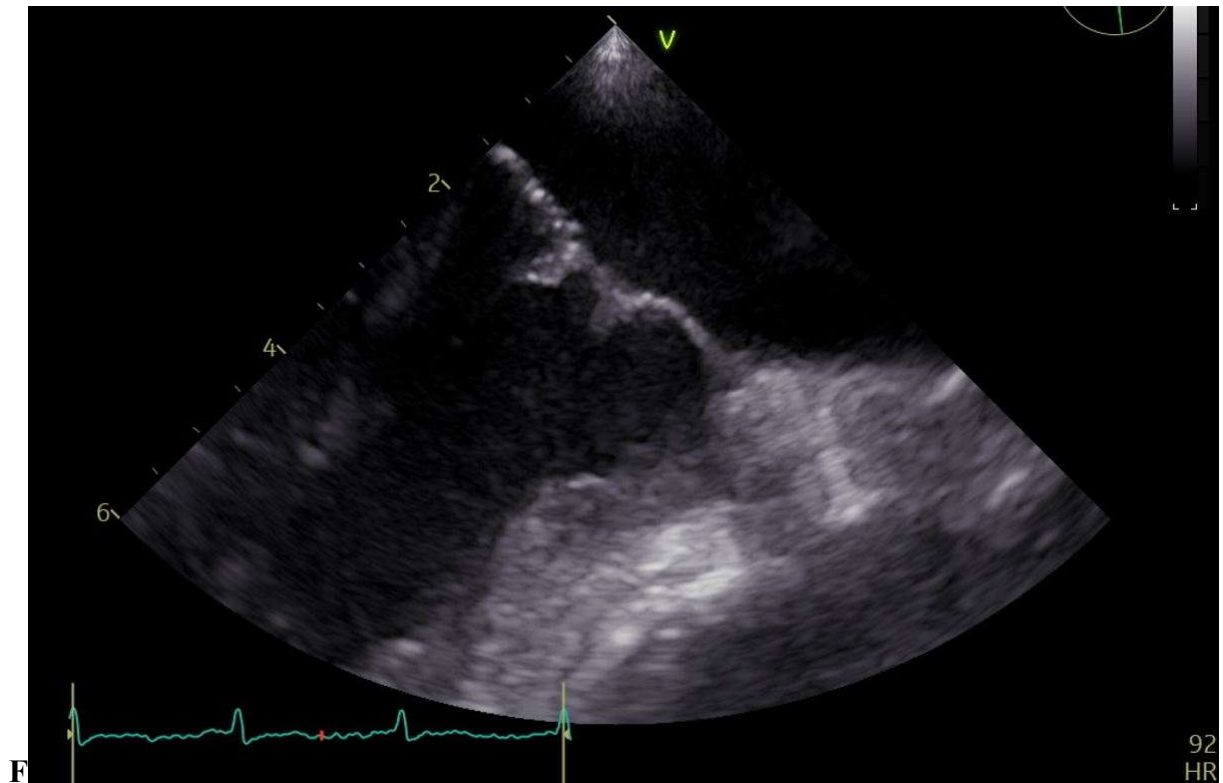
A. Severe mitral regurgitation (MR) in the 4-chamber view on transthoracic echocardiography (TTE); vena contracta measures 9 mm. B. Central large jet >50 % of the left atrium area. C. Severe MR in the 3-chamber view on TTE; proximal isovelocity surface area measures 10 mm. D. Mild to moderate MR in the 4-chamber view on TTE after 5 days of treatment E. Mild to moderate MR in transesophageal echocardiography (TOE) after 5 days of treatment. F. Rheumatic changes of the mitral valve observed on TOE
